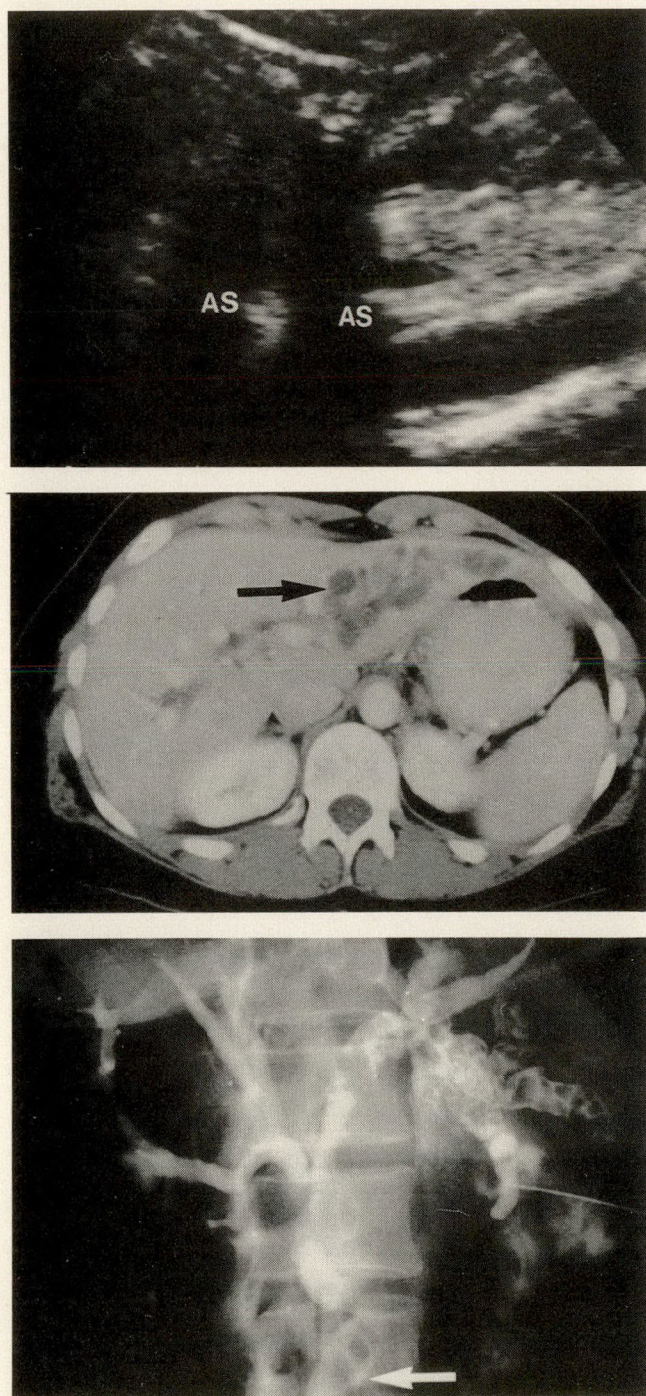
Radiologic findings in patient with multiple intrahepatic cholesterol stones. (Top) Ultrasonogram of left hepatic lobe shows dilated bile ducts which contain multiple acoustic shadows (AS) of various sizes. (Middle) Computed tomography scan confirms dilatation of intrahepatic biliary tree, particularly on left (arrow), with no sign of external compression. (Bottom) Percutaneous transhepatic cholangiogram demonstrates hundreds of stones of many sizes within large and small ducts of left hepatic lobe, extending into common bile ducts (arrow).
